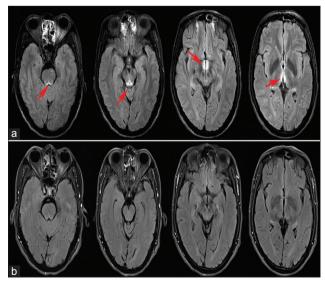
High signal lesions in brain magnetic resonance imaging results of the patient before receiving thiamine therapy, as indicated by the red arrows (a). Magnetic resonance imaging results of the patient after receiving thiamine therapy for 3 months (b).
